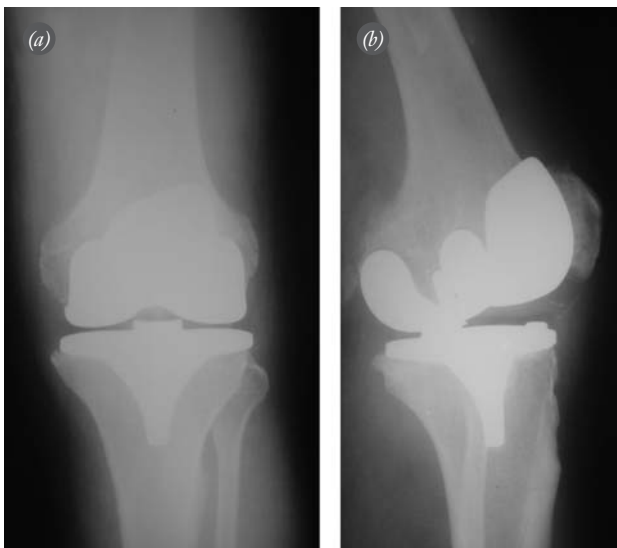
(a, b) Preoperative knee X-rays of the patient.
